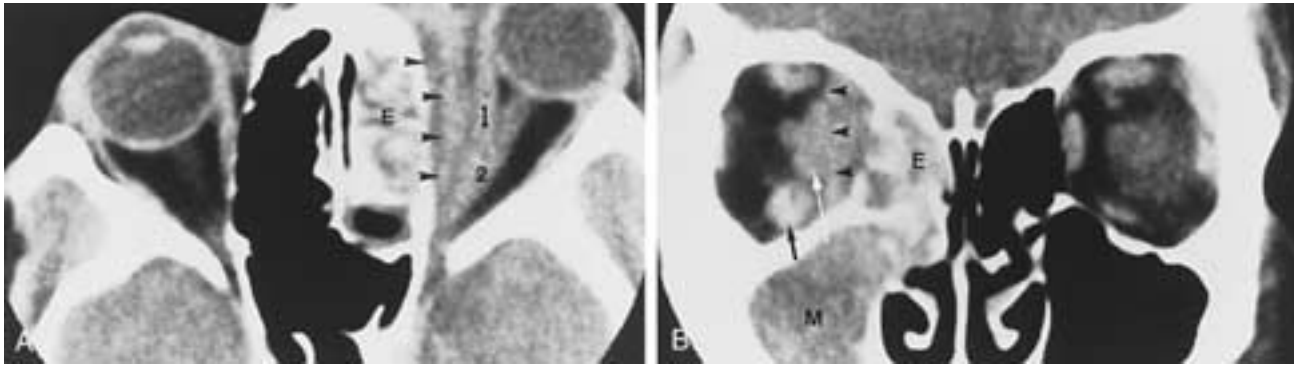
Orbital subperiosteal phlegmon. A, Axial CT scan shows proptosis of the left eye with mucoperiosteal thickening of the left ethmoid sinus (*E*), with soft-tissue induration in the medial subperiosteal space (*arrowheads*). Note the lateral displacement of the inflamed left medial rectus muscle (*I*). Optic nerve (*2*). B, Coronal CT scan, same patient as in A, shows clouding of the right ethmoid (*E*) and maxillary (*M*) sinuses, with subperiosteal soft-tissue induration (*arrowheads*) and swelling of the right medial rectus muscle (*white arrow*) and right inferior rectus muscle (*black arrow*). (From Mafee MF et al. CT assessment of periorbital pathology. In: Gozalez CA, Beeker MH, Flanagan JC, eds. *Diagnostic Imaging in Ophthalmology*. New York: Springer-Verlag, 1985;281–302.)
